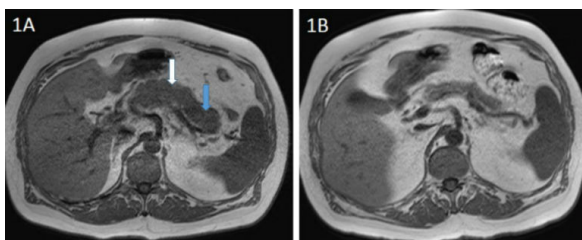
1A-Non-contrast T1 MRI showing diffuse pancreatic body (white arrow) and tail (blue arrow) enlargement in patient with type 1 autoimmune pancreatitis. 1B-Improvement in pancreatic morphology following glucocorticoid therapy.
